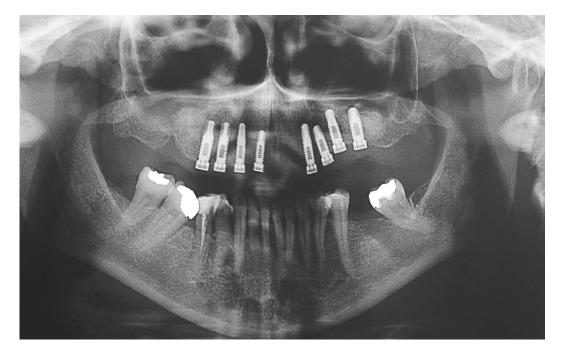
Panoramic radiograph after implant placement surgery (Case 2).
